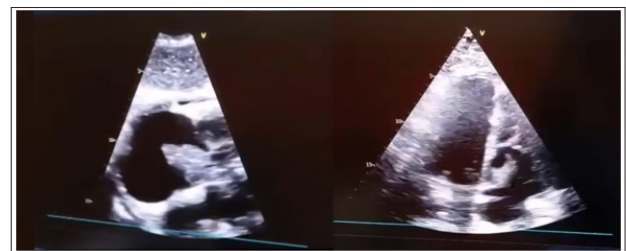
Subcostal and Apical Four-Chamber Views by Transthoracic Echocardiography
